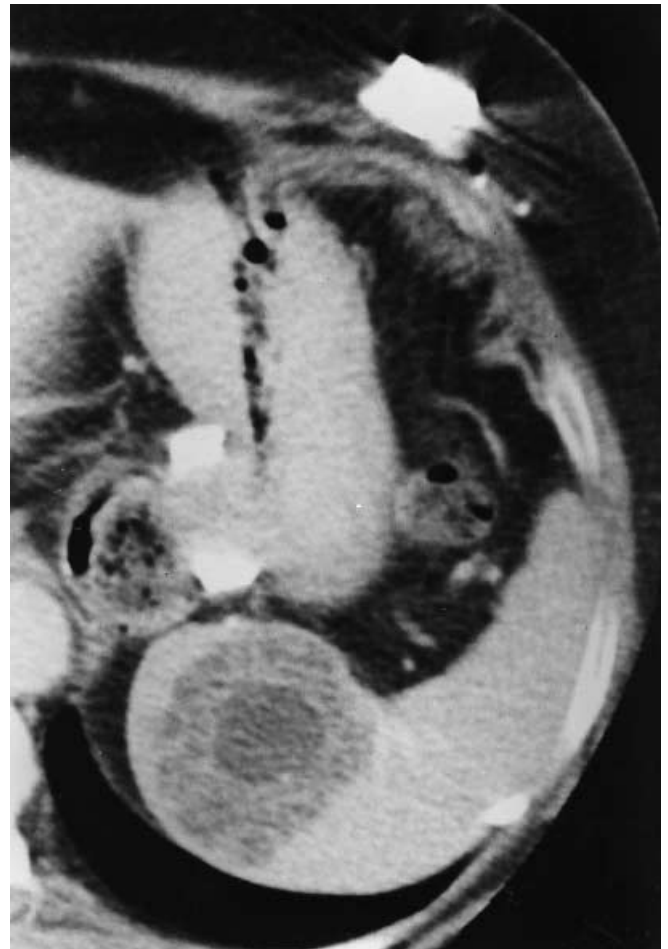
Contrast-enhanced CT scan. The study confirms the presence of a large central cyst surrounded by smaller cysts. The septa between the cysts are barely visible and enhance to the same extent of the splenic parenchyma. No calcifications are seen. There is a hyperdense ring around the stomach due to a previous gastric banding procedure
